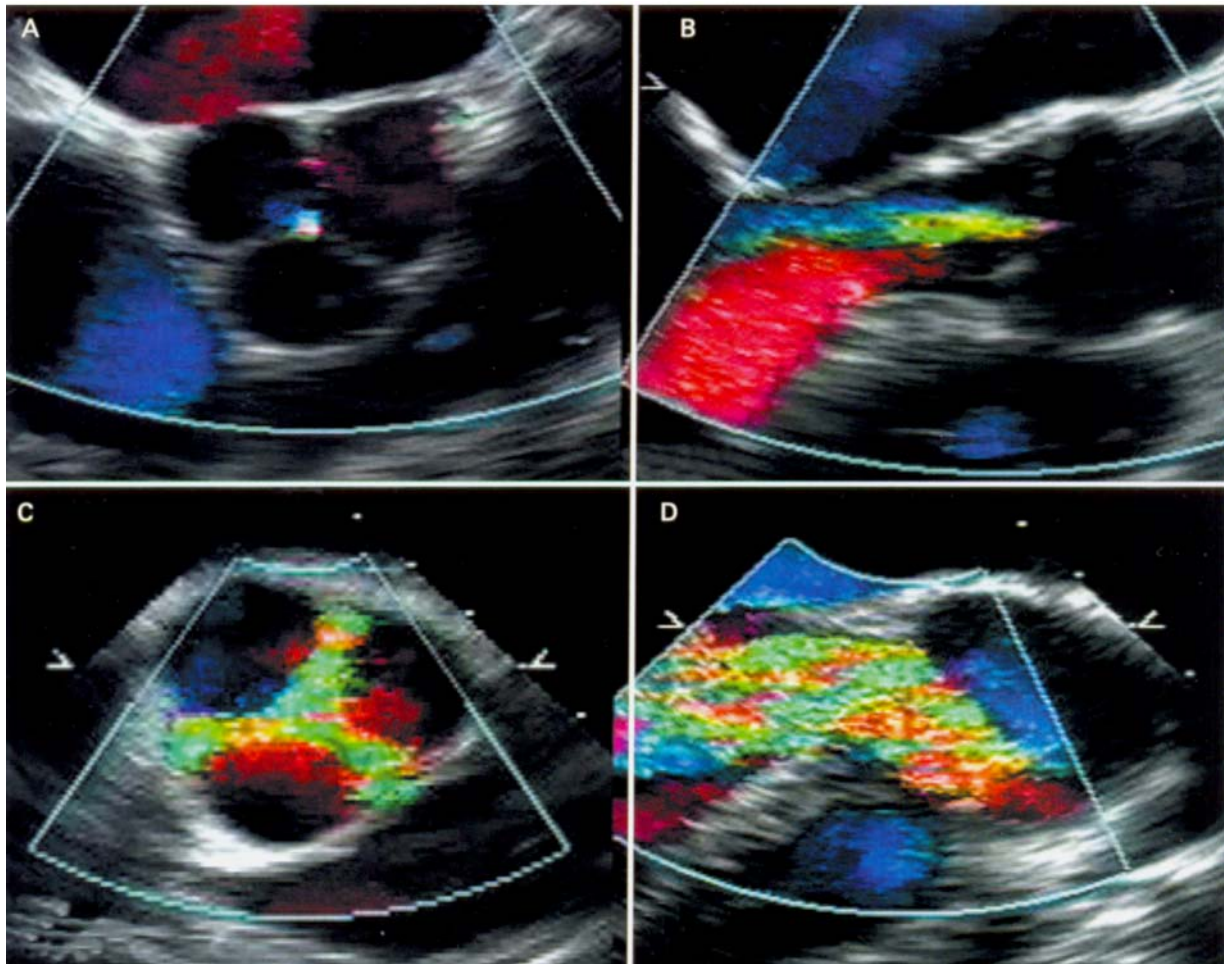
Colour flow Doppler of aortic regurgitation (AR). (A) Mid-oesophageal short-axis view of an aortic valve with mild (+) AR showing a small, central regurgitant orifice. (B) Mid-oesophageal long-axis view of the same valve as in panel A, showing a narrow jet of AR confined to the left ventricular outflow tract. (C) Mid-oesophageal short-axis view of an aortic valve with severe AR due to annular dilation. There is regurgitation visible through the entire surface of cusp coaptation. (D) Mid-oesophageal long-axis view of the same aortic valve as in panel C, showing a wide jet of AR extending into the left ventricle. This view was made to optimise the image of the AR and does not show the true diameter of the aortic valve annulus, which was 3.5 cm.
